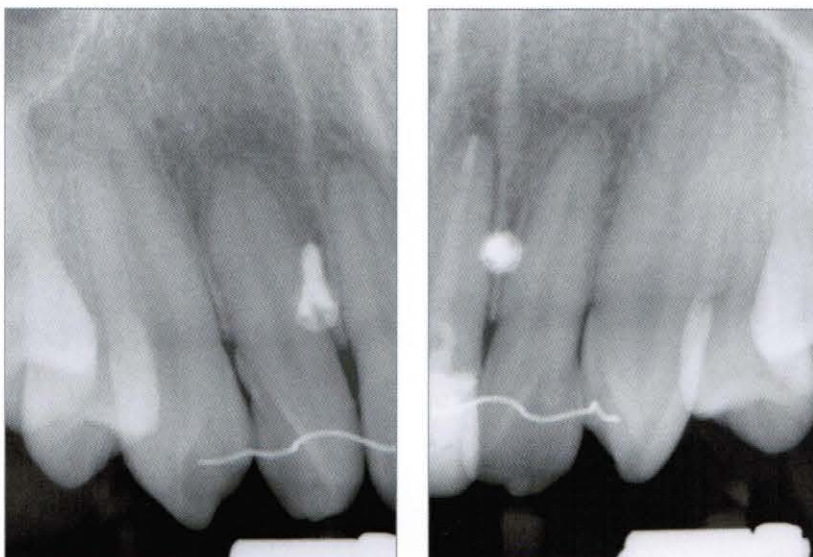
Periapical radiographs taken after inserting 1.6×6.0mm mini-implants between the upper central and lateral incisors on both sides (2007, 4,10).
